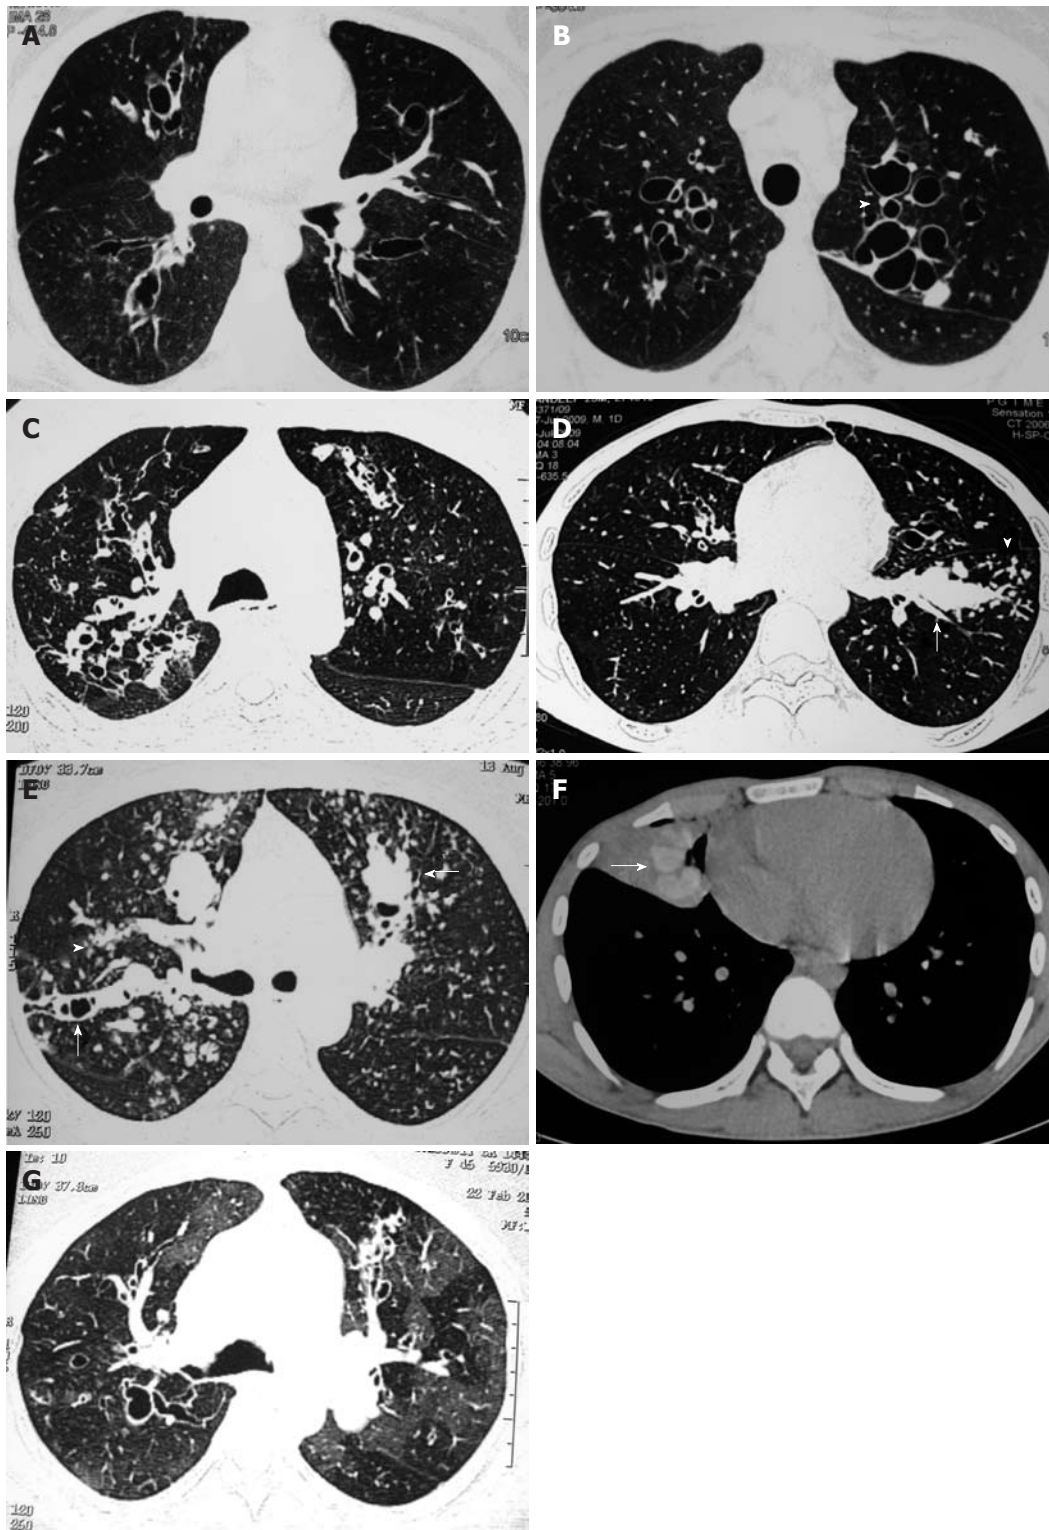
High resolution computed tomography chest scan. A, B: High resolution computed tomography chest scan showing typical central bronchiectasis. The upper panel shows cylindrical bronchiectasis while the lower panel shows cystic bronchiectasis; C: High resolution computed tomography chest scan showing bronchiectasis extending to the periphery. Also seen are mosaic attenuation and centrilobular nodules; D, E: High resolution computed tomography chest scan demonstrating mucus plugging of dilated bronchi (arrows) with evidence of centrilobular nodules in a tree-in-bud fashion (arrowheads); G: High resolution computed tomography chest scan showing central bronchiectasis with extensive areas of mosaic attenuation.
